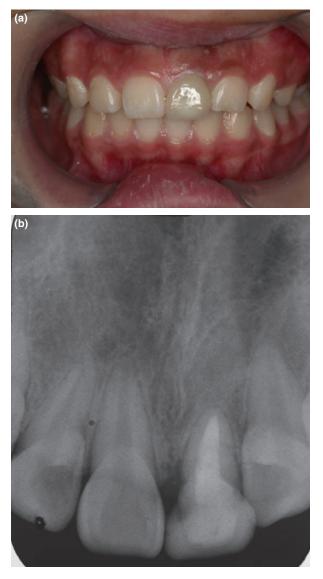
Tooth at 3.5-year recall. (a) Functionally and esthetically acceptable ceramic crown. (b) Radiographic view.
